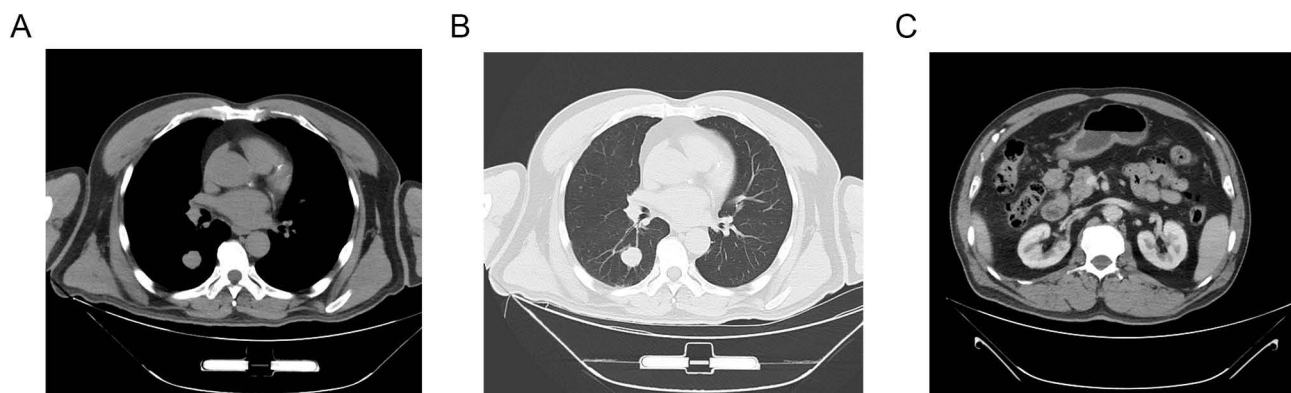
The baseline CT scan results of the patient's chest and abdomen (July 15, 2022). (A) The patient's chest CT mediastinal window reveals multiple solid nodules in both lungs, with the largest located in the right lower lobe (2.3 \times 2.2 cm). (B) Patient's chest CT image in lung window. (C) The abdominal CT scan reveals thickening of the greater curvature wall of the stomach, thickening of the gastric fundus, and metastatic lymph nodes around the stomach (2.0 \times 1.7 cm).
